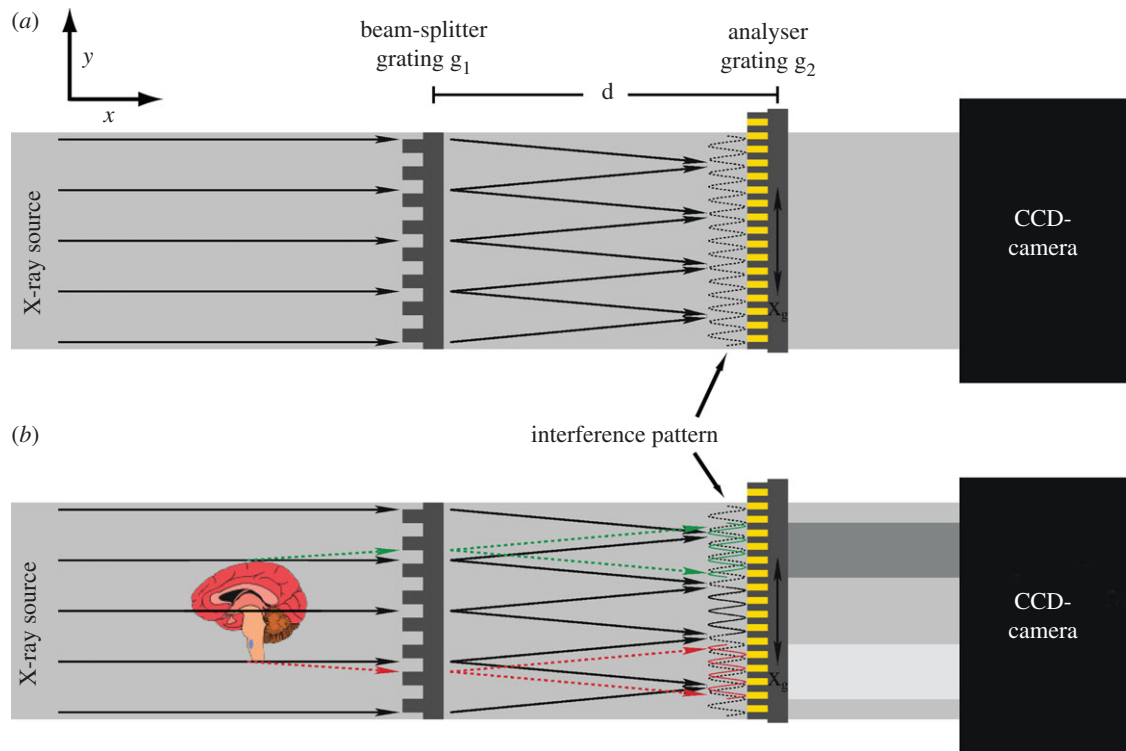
Top view of the experimental set-up consisting of the detector and the grating interferometer composed of a beam-splitter and an analyser grating. The x - and y -axis form a horizontal plane in which the coordinate x corresponds to the beam direction. The z -axis is oriented parallel to the x - y -plane in the direction of the viewer. The tomography rotation axis is oriented parallel to the z -axis. A phase object causes slight deflection of the incoming X-rays.
